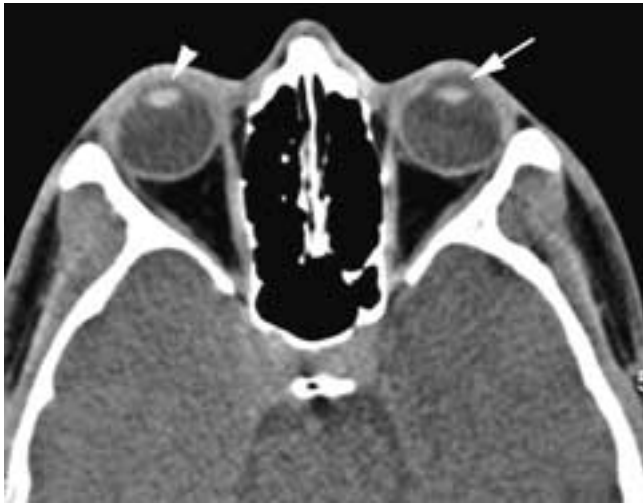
Perforation of the cornea. Axial CT scan shows perforation of the cornea with hypotony of the aqueous chamber. The fluid space between the cornea and the lens on the right side (*arrowhead*) is diminished compared to the left. A normal aqueous chamber is seen on the left side (*arrow*).
